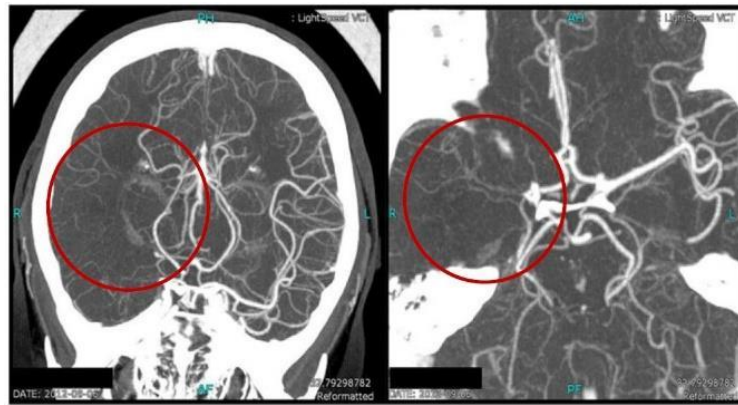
A CTA scan showing absence of the middle cerebral artery (MCA) (red circle) on the right hemisphere (left in the image). Image courtesy to (5).
